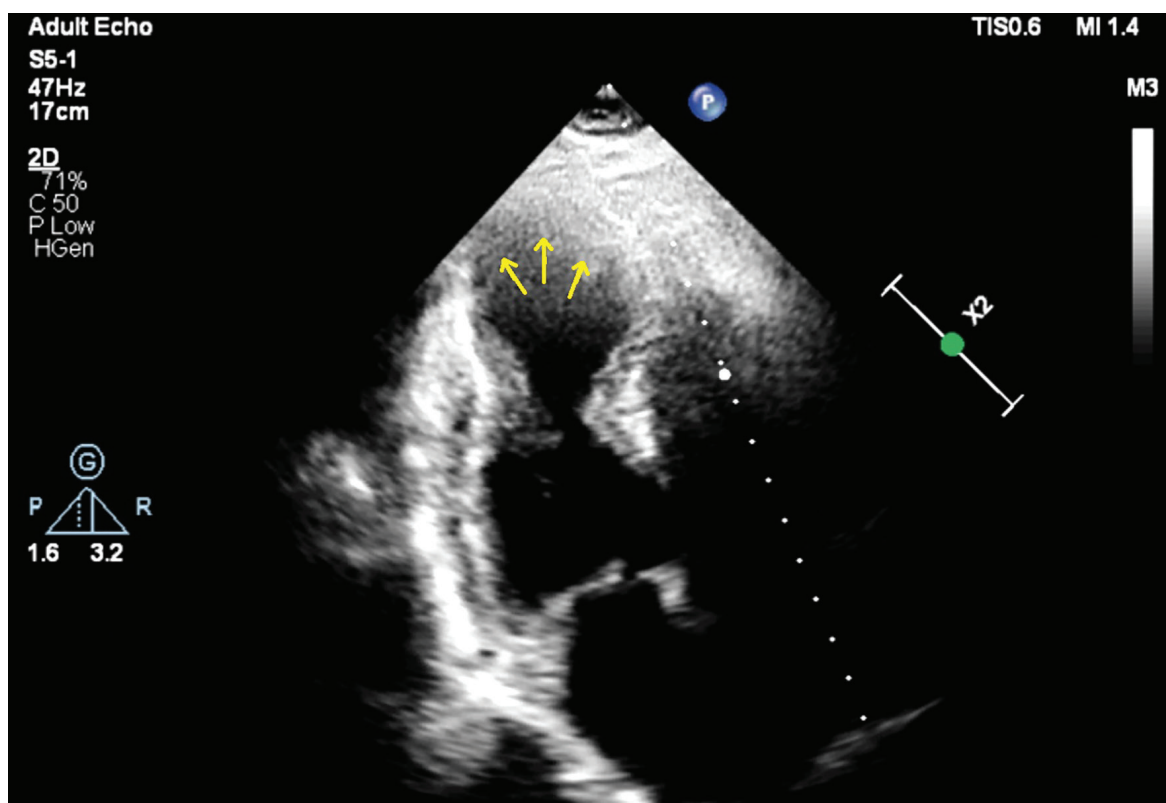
Transthoracic echocardiographic apical four-chamber view showing apical ballooning with akinesia of the apex and hyperkinesis of the basal segments, consistent with a Takotsubo-like pattern
